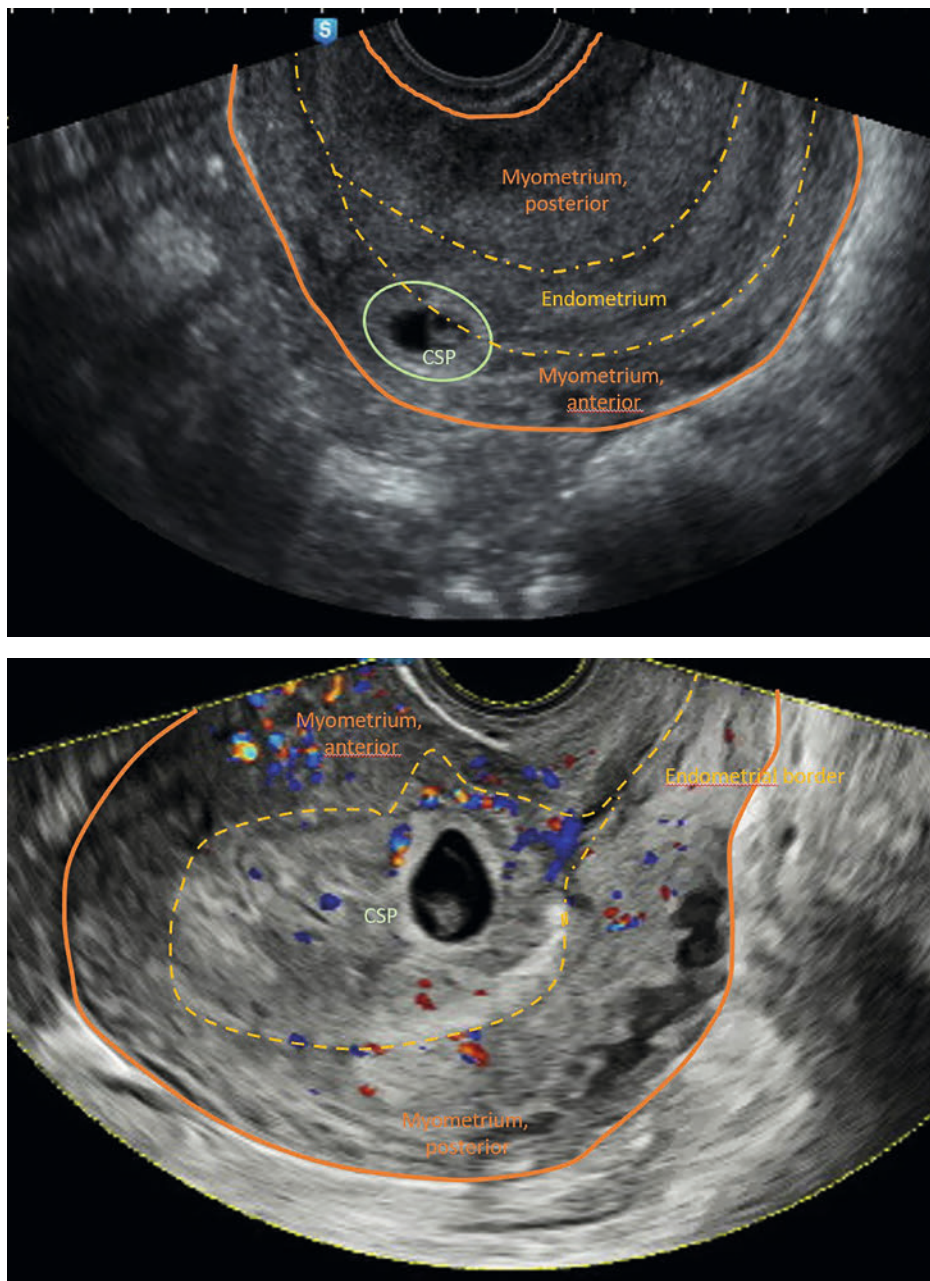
Example of a Cesarean scar pregnancy with the largest part of the gestational sac located in the myometrium, which progressed to intrauterine pregnancy with advancing gestation (1 week difference between ultrasound images).
